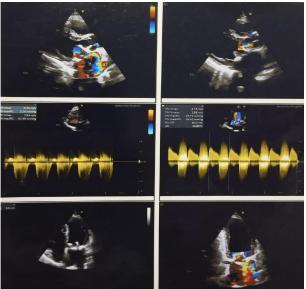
Preoperative color Doppler echocardiogram showing a dysfunctional bioprosthetic mitral valve with elevated pressure gradients.
